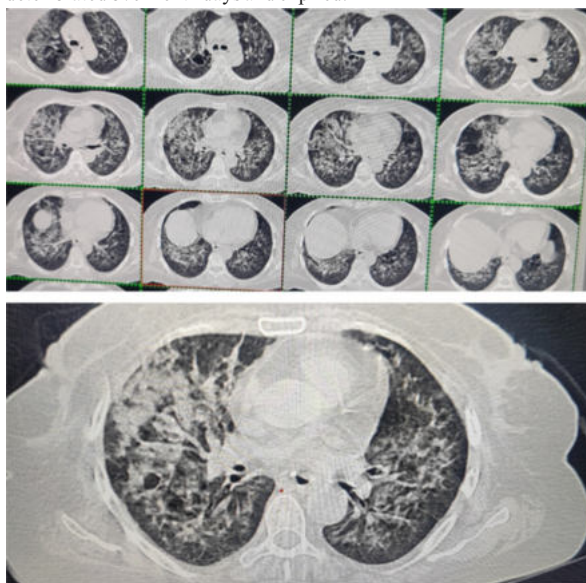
HRCT thorax showing diffuse area of ground glass opacities, approximately 80% involvement with bronchiectatic changes in upper and lower lobes.
